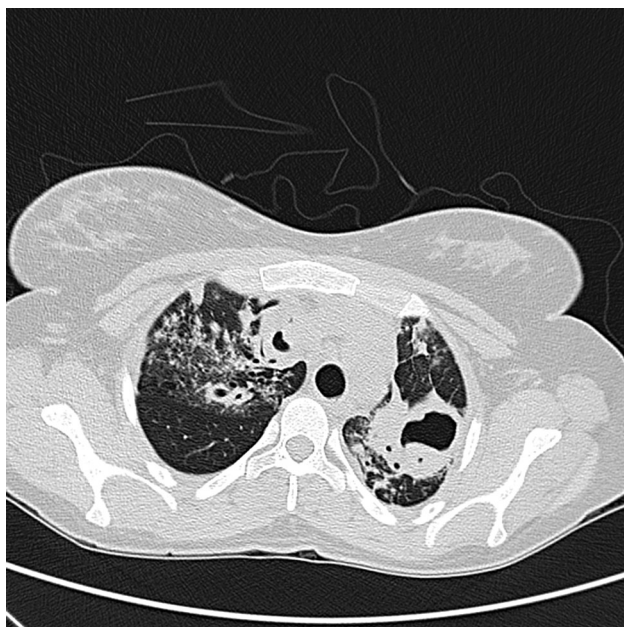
CT image: presence of tubercular cave in left upper lobe of approximately 5 cm surrounded by inflammatory thickening air bronchogram; two other excavated lesions are present in the upper right lobe.
